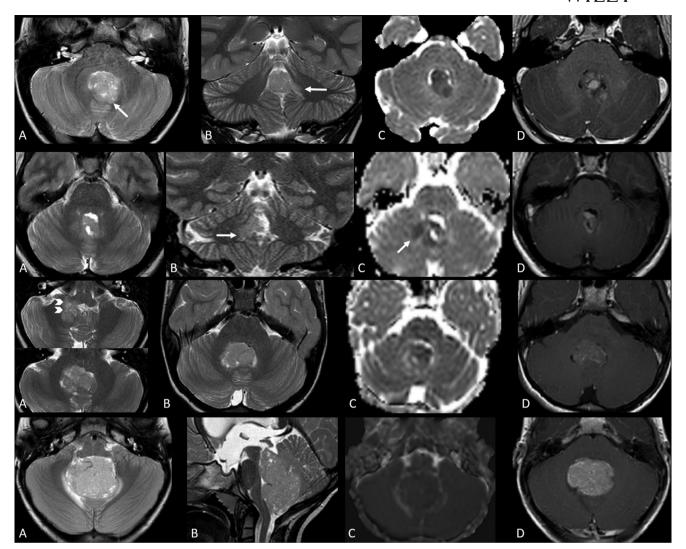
Brain MRI in cases 1-4. T2-wi (A,B), ADC (C), and T1-wi after contrast medium (D) showing tumors in the posterior fossa located in the fourth ventricle. In cases 1-3, the masses appear to be gross midline, with no definite laterality. Note involvement of the left (case 1) and right (case 2) postero-lateral recesses of the fourth ventricle in subtype B (arrows), and of the right antero-lateral recess of the fourth ventricle in subtype A (arrowheads in case 3). In case 4, the tumor is midline, with no obvious laterality. Subtype A is the most central of all WNT medulloblastomas.¹⁴ All tumors show similar signal abnormalities and enhancement patterns
